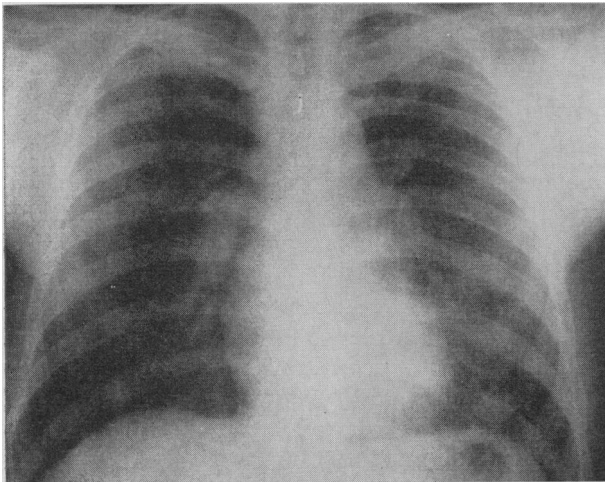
Chest radiograph of recipient early in his disease (March 1964).
